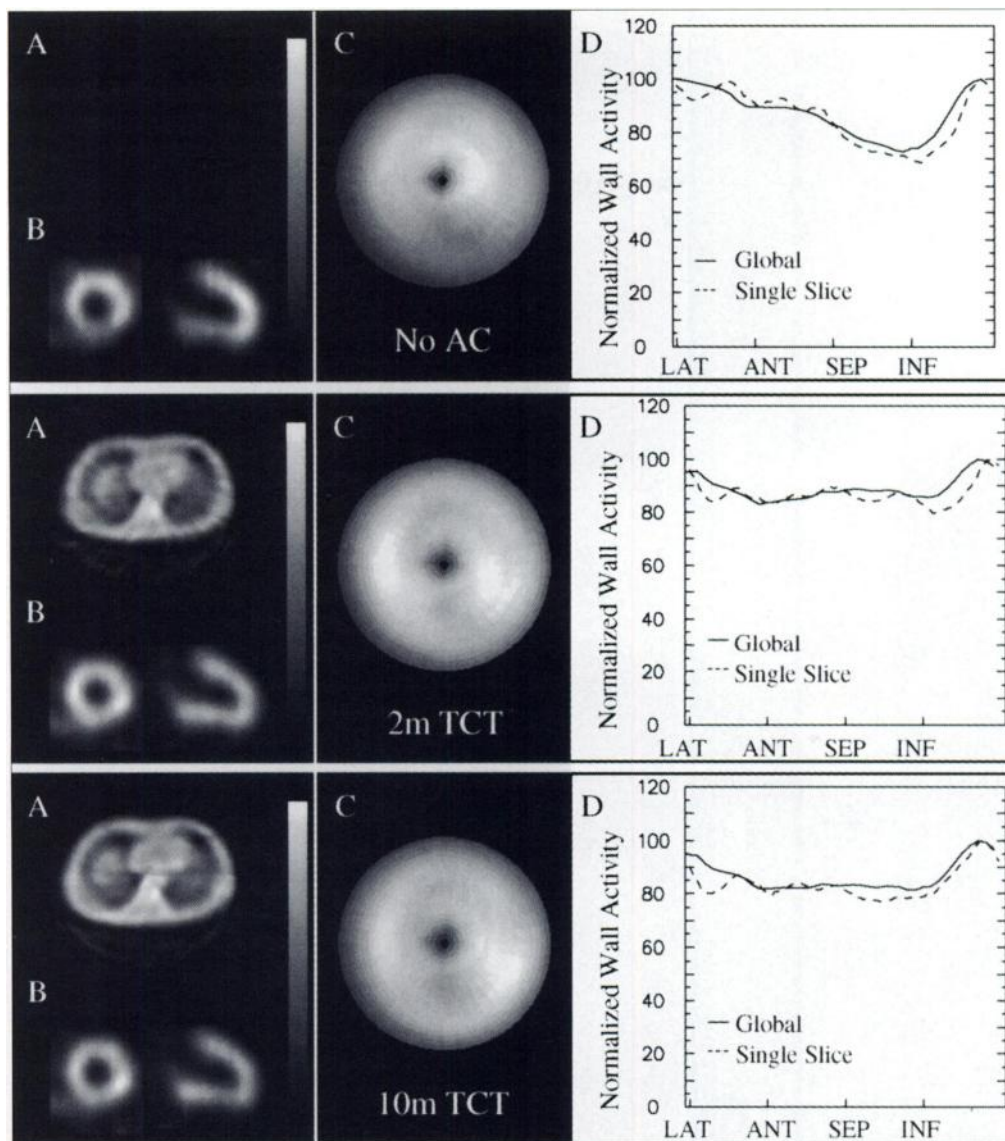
Results of NC and AC rest ^{201}Tl SPECT imaging for Patient 1. This individual was a 44-yr-old male volunteer without any history of cardiac disease. (A) Single-pixel-thick slice of TCT. (B) Short-axis and vertical long axis slices through region of myocardium that demonstrates most significant attenuation on NC study. (C) Polar map of SPECT data. (D) Summed circumferential profiles for SA slice shown in B and for myocardium as a whole (global profile).
